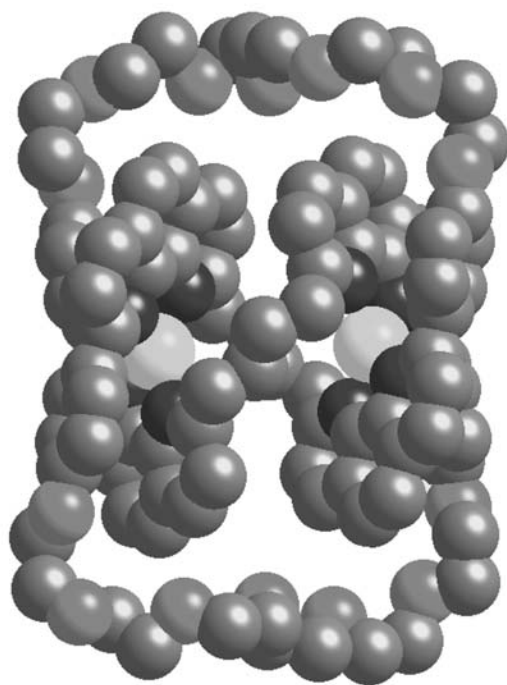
X-ray structure of the knot 14^{2+} [59]
